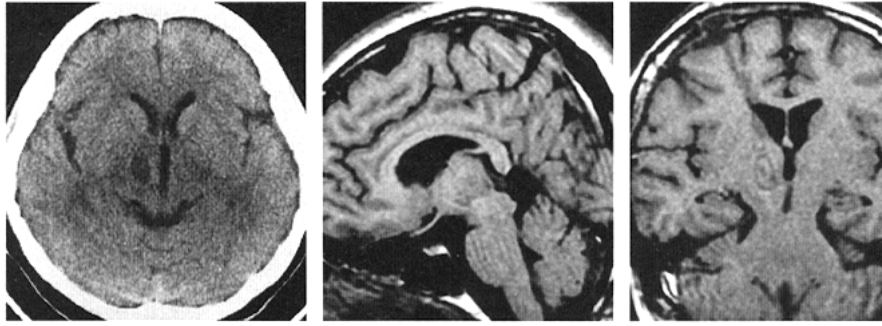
Postoperative CT scan and T1-weighted MR images. *Left*, CT scan performed 14 days after surgery showing total resection of the angioma and improvement in the ventricular dilatation. *Middle*, MR sagittal image obtained during the fourth postoperative week showing total resection of the angioma and the normalization of the configuration of the midbrain and the diencephalon. *Right*, MR oblique image, 45 degrees from the AC-PC line, obtained during the fourth postoperative week, demonstrating the fine line of the trajectory used to resect the angioma from the frontal burr hole through the anterior limb of the internal capsule.
